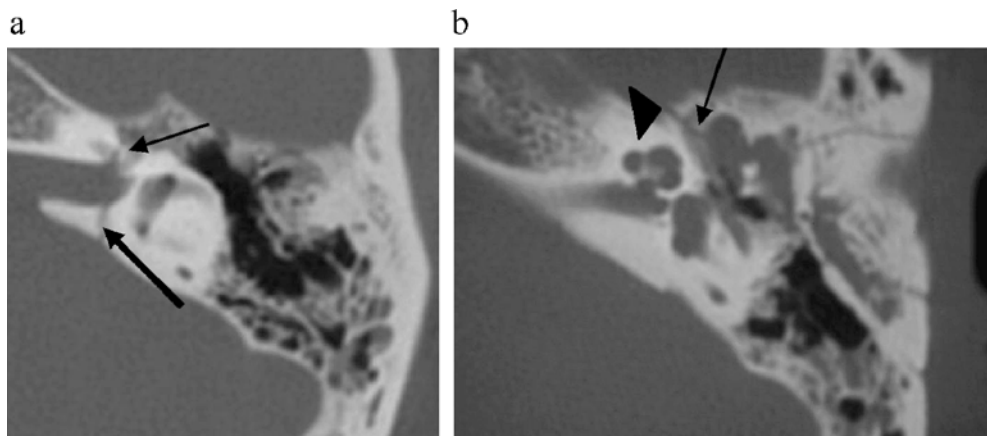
Fractures of the temporal bone affecting the facial nerve canal. Axial CT images on bone windows. a Shows a transverse fracture line through the short axis of the left temporal bone, crossing the internal auditory canal (thick black arrow), the basal turn of the cochlea and the labyrinthine segment of the facial nerve
